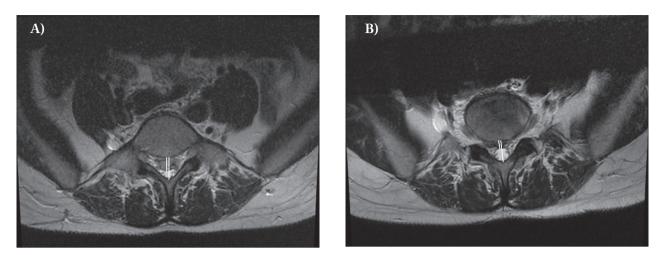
Axial T2 image at MRI evaluation of percentage of expulsion pre (A) and post coblation (B) in a 39-year-old woman with a large migrated herniation at L5
